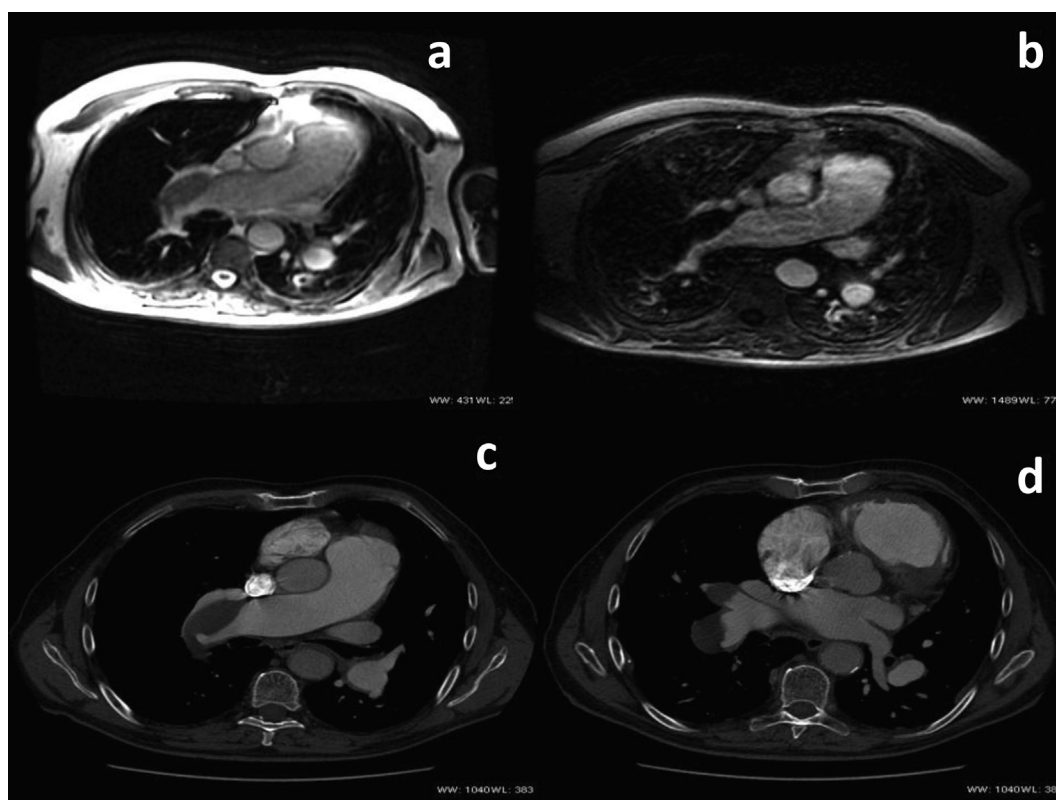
Imaging results. (a) Steady-state free precession (SSFP) images showing main and right pulmonary artery dilatation and a right pulmonary artery lumen reduction that is compressed by hypodense mass (thrombosed false lumen). (b) Contrast enhanced-magnetic resonance angiography (CE-MRA) showing main and right pulmonary artery dilatation with right pulmonary artery perfusion defect. (c) Angio-computed tomography (CT) images showing main and right pulmonary artery dilatation with right pulmonary artery dissection; a true and a thrombosed false lumen are visualized. (d) Angio-CT images showing a hypodense formation at the right pulmonary artery bifurcation; this formation was not enhanced during angiography and venous phase images.
